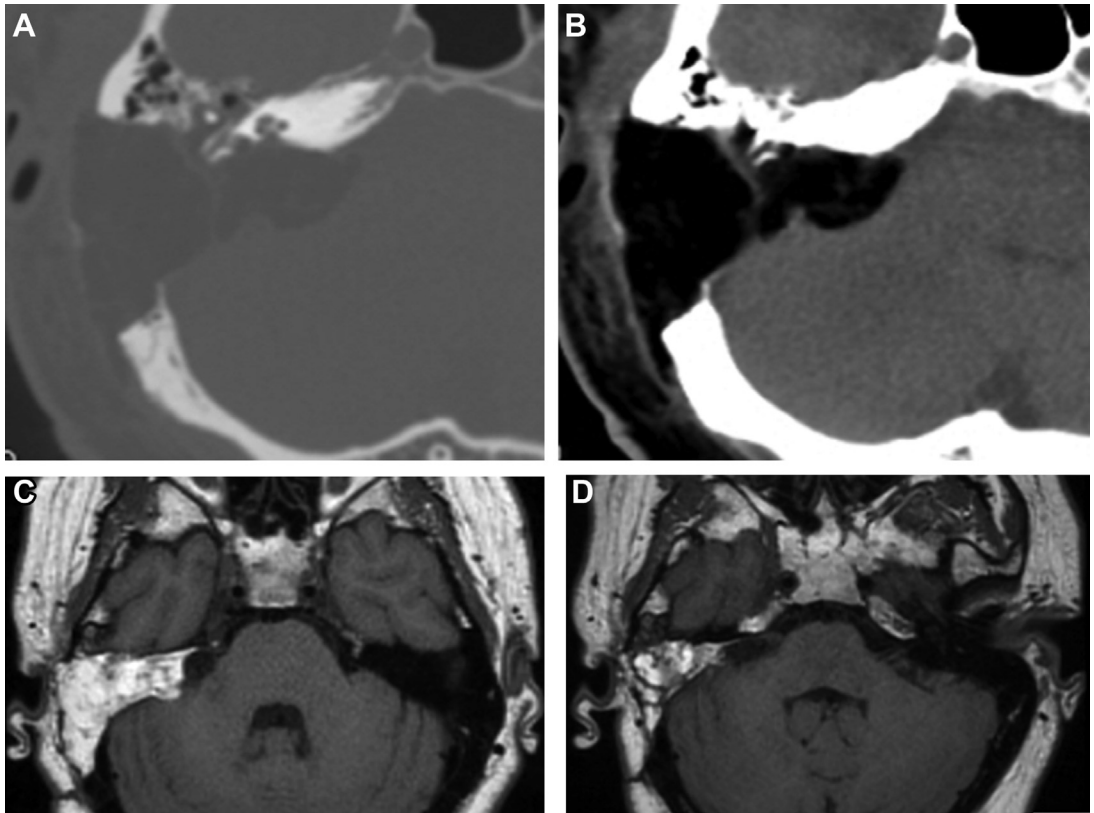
Translabrynthine postsurgical appearances. CT axial with (A) bone and (B) soft-tissue windows indicating the expected petro-mastoid bony defect and fat graft to the subtotal petrosectomy cavity. T1w axial images (C) 3 months after surgery and (D) 4 years after surgery demonstrate interval involution of the fat graft.
